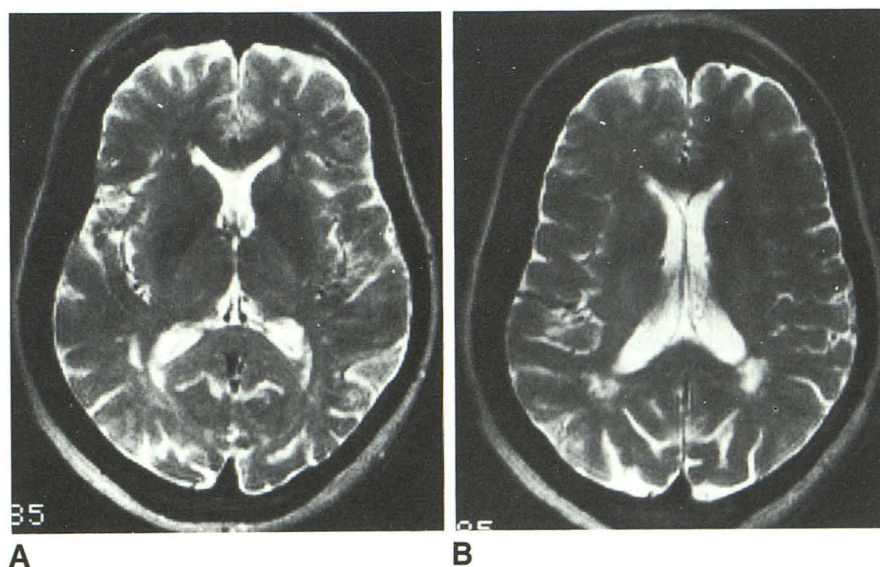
Case 2: 50-year-old hypertensive woman with systemic sarcoidosis, sarcoid ophthalmopathy, cranial-nerve palsies, and abnormal CSF studies. MR images, 2000/20 (TR/TE), show closely periventricular lesions at lower (A) and higher (B) ventricular levels.
